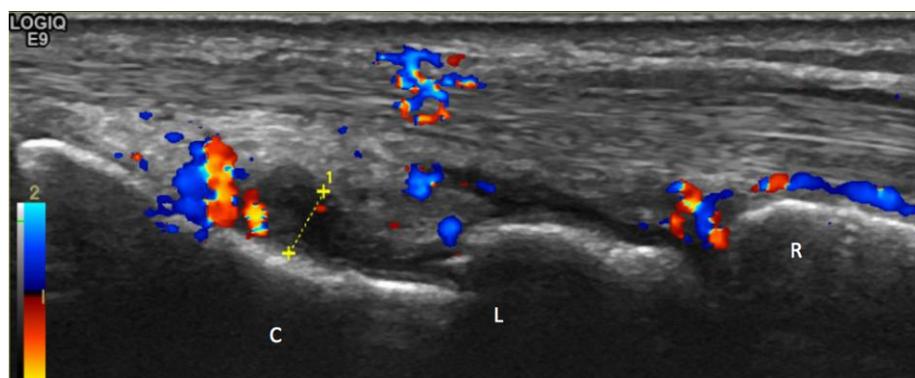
Sonography of the wrist.
